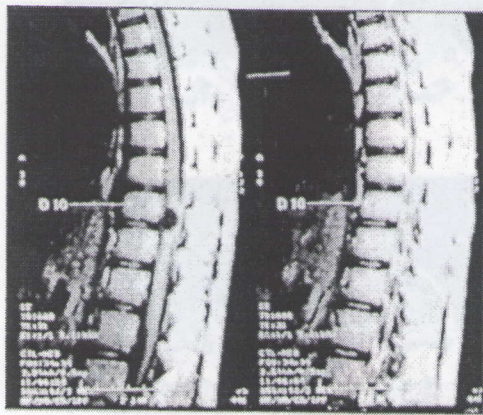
MRI showing arachnoid cyst at D10.
